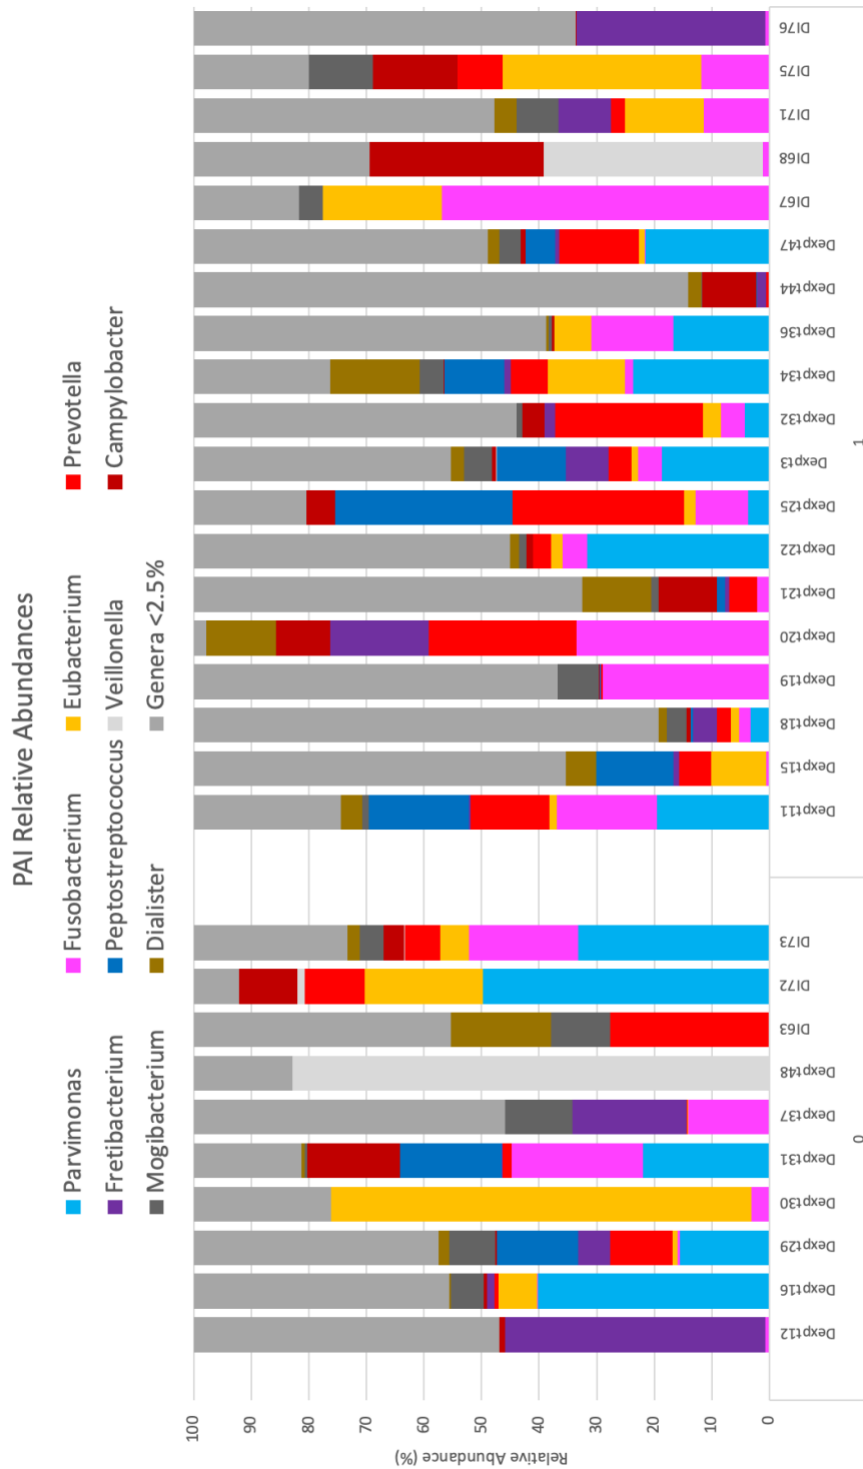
Prokaryotic composition of non-surgical samples related to Periapical Index score. Relative abundances of predominant genera. Genera reflecting a mean < 2.5% of sequence reads among all samples was consolidated. 0= PAI 2, 1=PAI 5.
